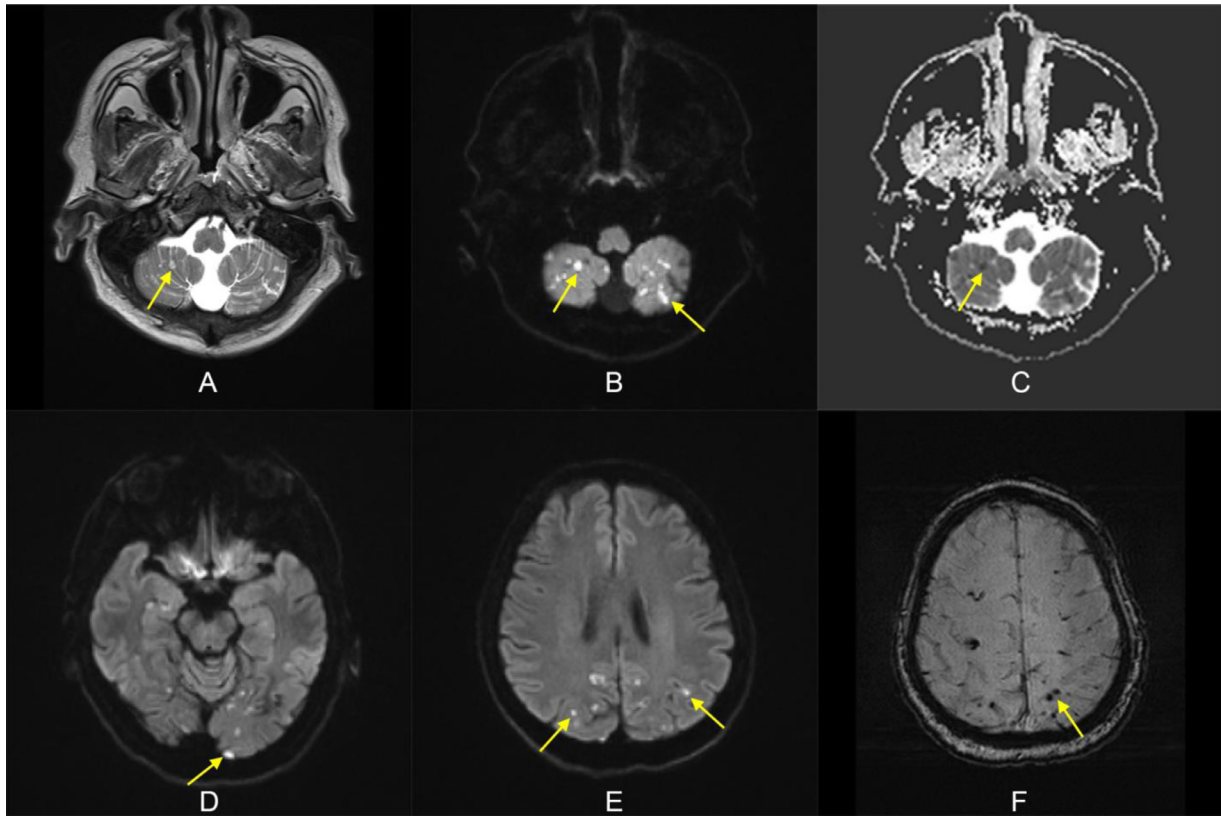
Initial magnetic resonance imaging of the brain: T2W, DWI, and ADC images (A–C) showing bilateral distribution of multiple small acute ischemic lesions and multilevel infarcts. The DWI images (B, D, E) showing restricted diffusion within the cerebellar hemispheres, as well as the temporal, parietal, and occipital cortex, primarily affecting the posterior circulation. The SWI images (F) reveal multiple old cerebral microbleeds, especially within the deep gray matter and posterior fossa."
